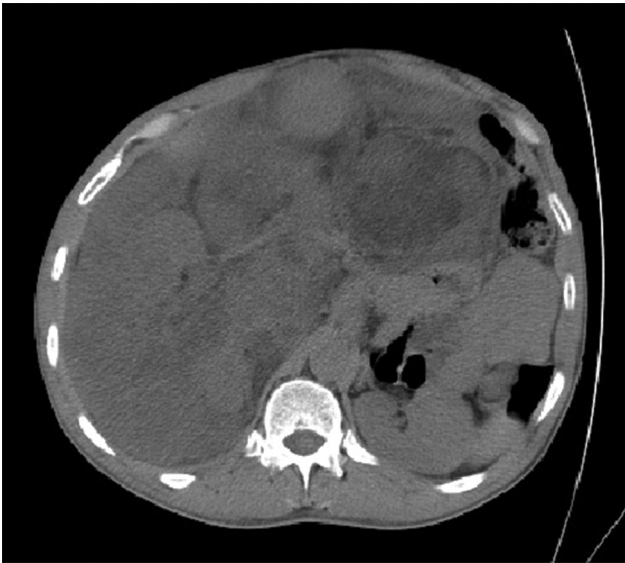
CT scan showing the large retroperitoneal sarcoma with abdominal structures being displaced to the left. CT, computed tomography.
